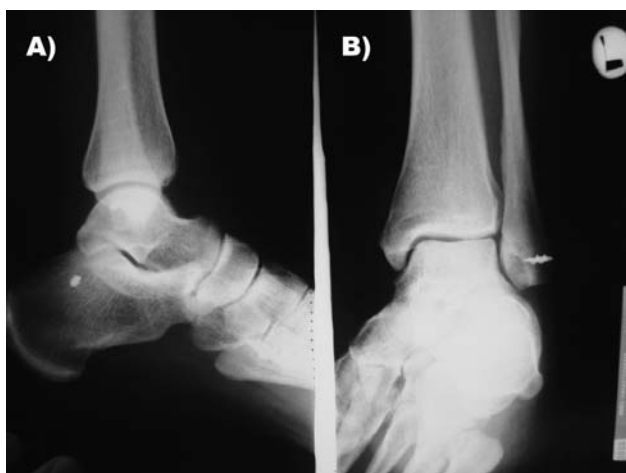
A) Fixation of semitendinosus graft with anchor sutures, where anchor is seen on the X-ray, and B) distally suturing the graft to the remainder of retinaculum.
